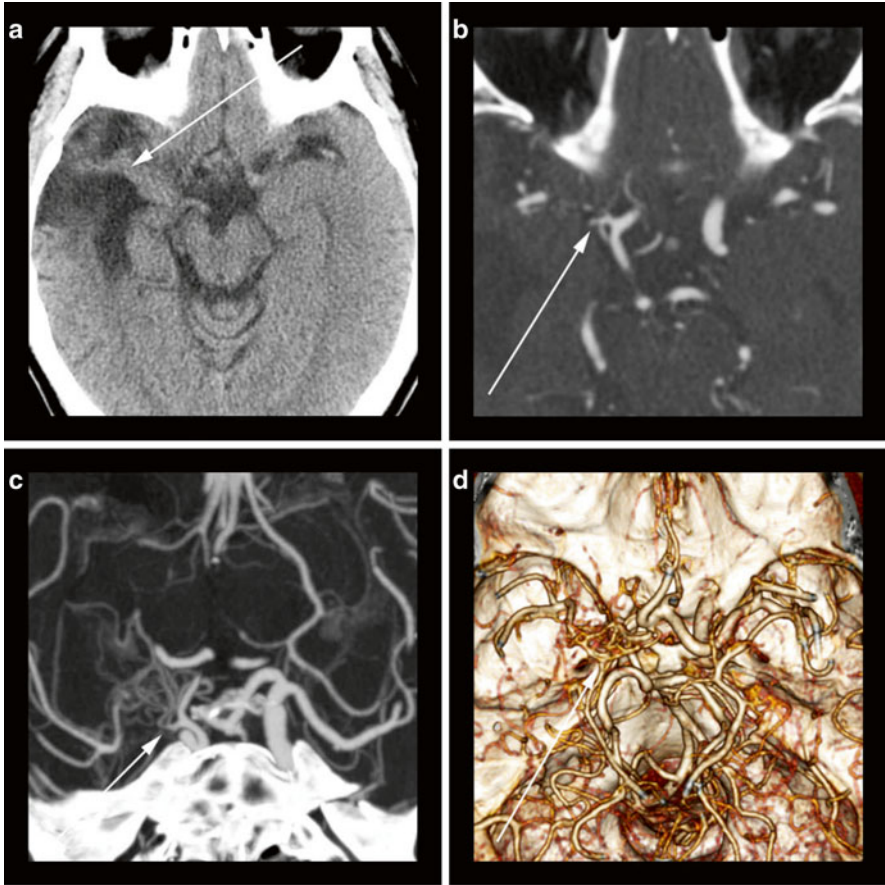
50-year-old male with history of chronic right middle cerebral artery infarction. (a) Noncontrast CT of the head reveals chronic encephalomalacia involving the right anterior temporal lobe (*arrow*) as well as *ex vacuo* dilatation of the right lateral ventricle. (b) Axial CTA image reveals findings of a critical and likely chronic stenosis of the right proximal M1 segment (*arrow*) of the middle cerebral artery. There is asymmetric increased size and opacification of the ipsilateral lenticulostriate vessels. (c) An oblique coronal orientation CTA MIP better displays the relationship of the middle cerebral artery stenosis (*arrow*) and the surrounding asymmetric dilated lenticulostriate vessels. (d) A 3D volume rendering from craniocaudal orientation reveals the “tangle” of dilated lenticulostriate vessels but obscures the underlying middle cerebral artery stenosis (*arrow*). An arteriovenous malformation could have a similar appearance from this reconstruction
